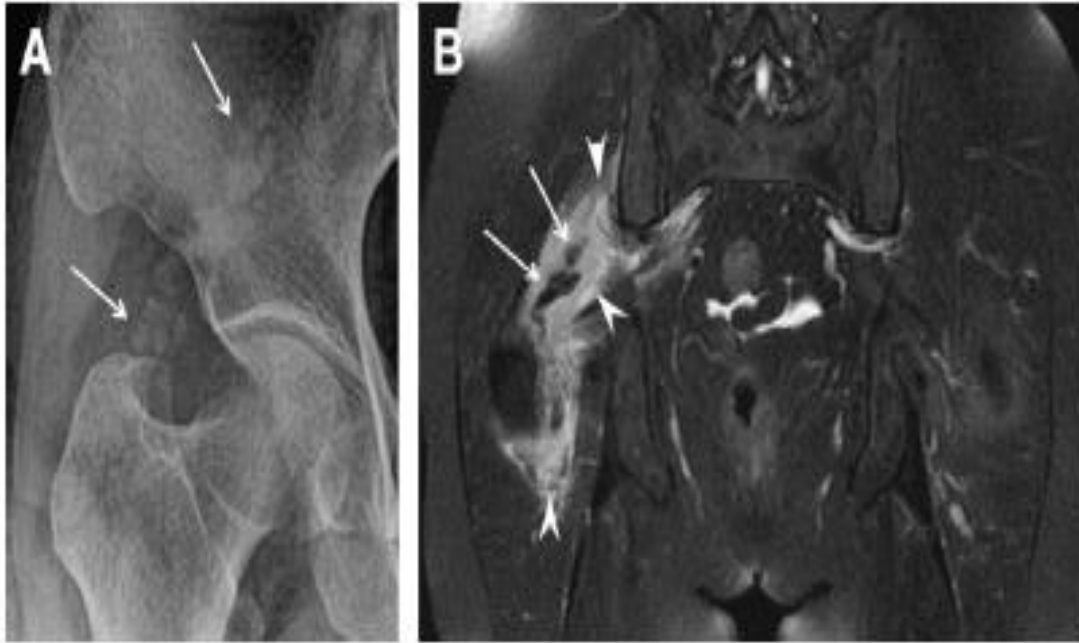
Patient 5: A 62-year-old female with a 2-day history of low back, buttock, and posterolateral thigh pain; images highlight extensive calcification of the superoposterior tendon. Anteroposterior radiograph of so-called aciniform calcifications, presenting as multiple, ill-defined, ovoid deposits (arrows) superior to the greater trochanter (A). Fat-suppressed T2-weighted coronal MR image, with effusion (arrowheads) surrounding the gluteus medius muscle and numerous low-signal aciniform calcifications (arrows) of the superoposterior tendon (B).
